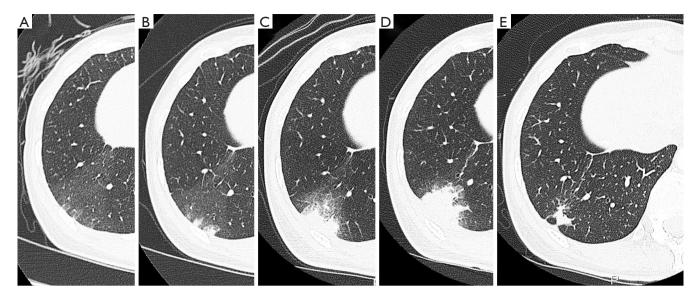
Time course of chest HRCT images. (A) Fan-shaped segmental GGO in the right lower lobe at presentation (first HRCT); (B,C) gradually enlarged parenchymal density in the GGO (B, two weeks after the first HRCT; C, four weeks after the first HRCT); (D) triangular structure with a broad pleural base surrounded by narrow GGO and accompanied by a linear strand at apex and small pleural effusion (six weeks after the first HRCT); (E) a small irregular shadow implying scar formation (three months after the introduction of anti-coagulant therapy). GGO, ground-glass opacity; HRCT, high-resolution computed tomography.
